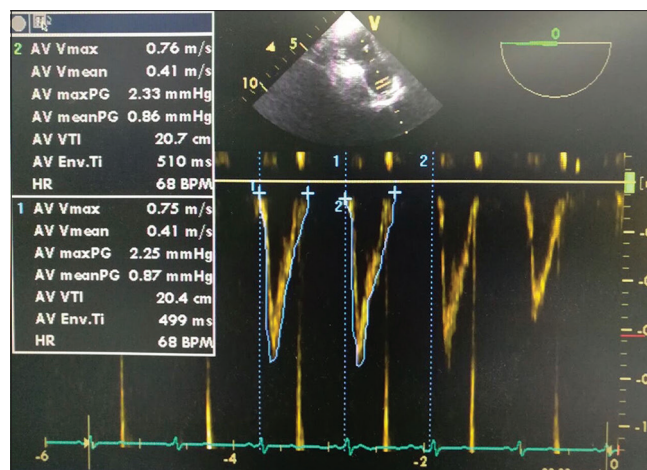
Transesophageal echocardiography image showing the deep transgastric long axis view with the Doppler cursor positioned at the aortic root. Velocity time integral of three consecutive Doppler waves recorded and averaged to get the desired values
